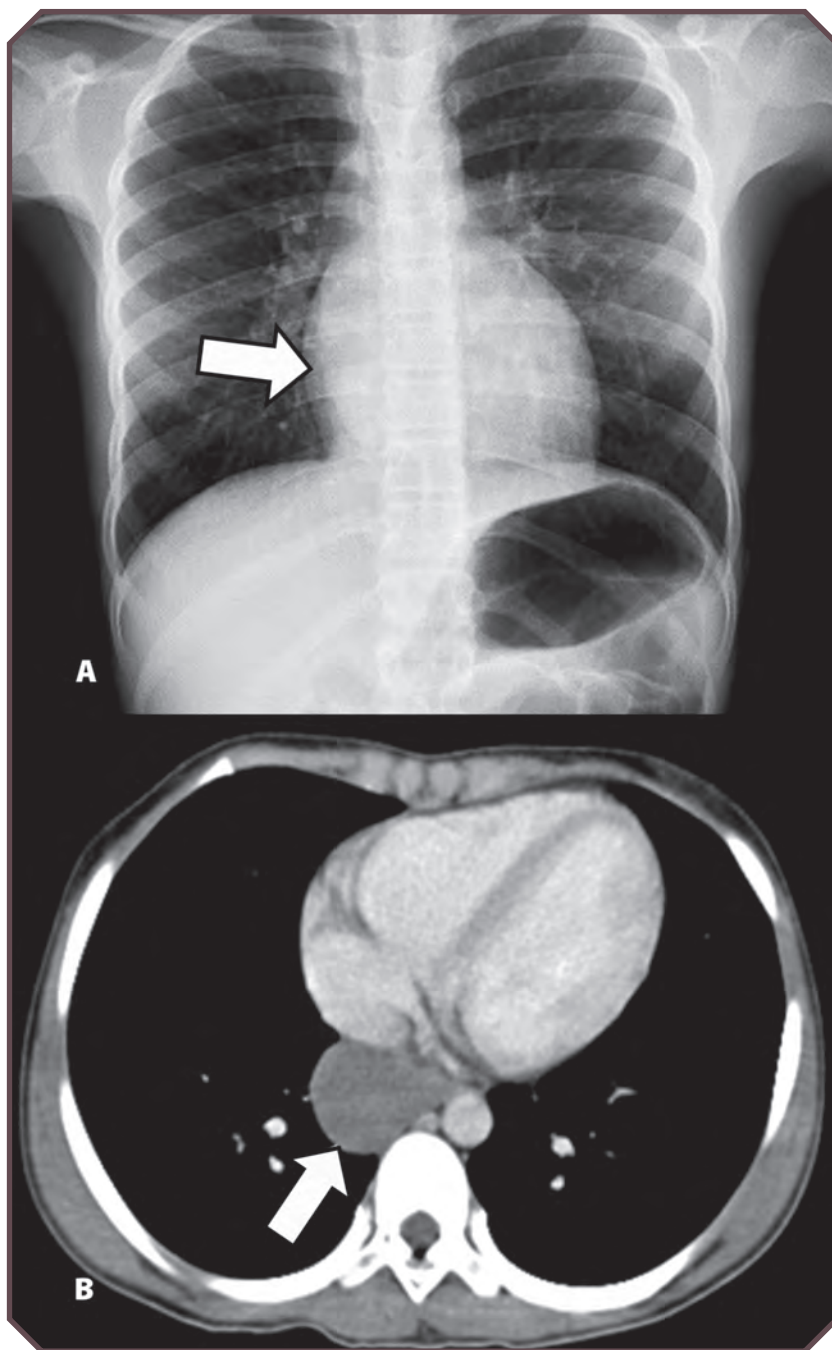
Esophageal duplication cyst in a 10-year-old girl with recurrent pneumonia. A. Frontal chest radiograph shows a well-defined retrocardiac mass (arrow). B. Axial chest computed tomographic image demonstrates a unilocular, fluid-attenuated (cystic), posterior mediastinal mass (arrow).
